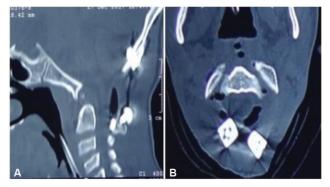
Postoperative computed tomography (CT) craniovertebral junction (CVJ). (A) Sagittal view showing occipital plate and C2 translaminar screw with reduction of atlantoaxial dislocation (AAD) and widening of canal. (B) Axial view showing bilateral C2 translaminar screw.
